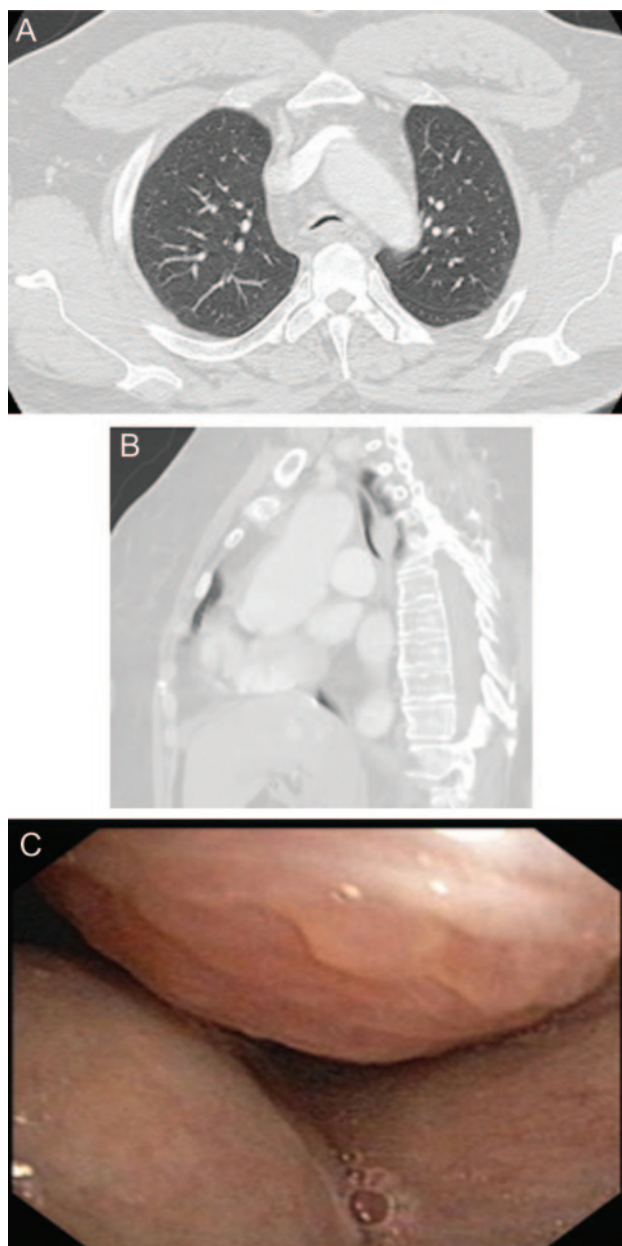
A: Pre-intubation chest computed tomogram image showing substantial narrowing of the distal tracheal antero-posterior diameter (crescent sign) with normal lung parenchyma. B: Lateral view shows gradual narrowing of tracheal antero-posterior diameter from proximal to distal end. C: Bronchoscopic image taken at the end of expiration with zero PEEP, demonstrating complete collapse of the trachea.
